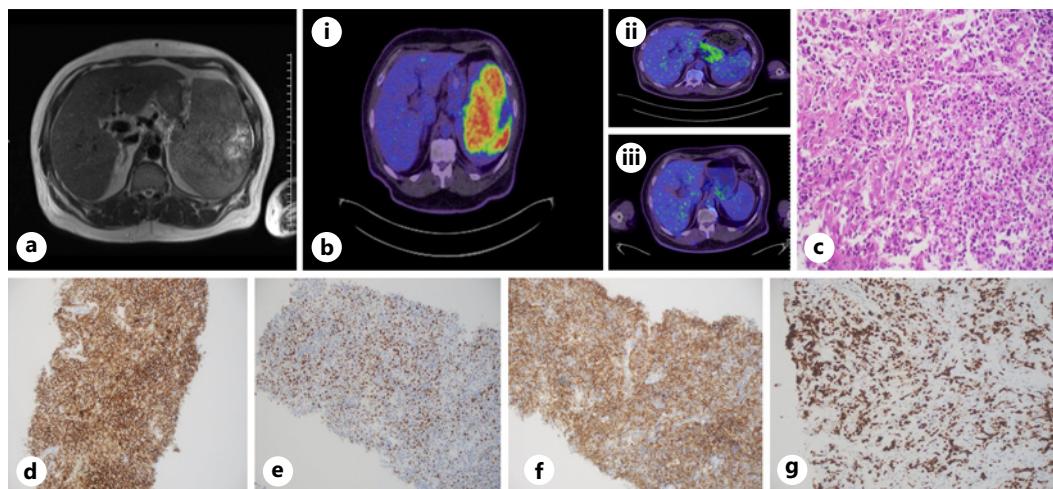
a Initial MRI of the abdomen. b-i Whole-body FDG PET CT. b-ii Interim NM whole-body PET CT. b-iii End of treatment, NM whole-body FDG PET CT. c Hypercellular lymphoid tissue (large lymphocytes and centroblasts). d Abnormal B lymphocytes showed strong positivity with CD20 at 20X power field. e Positive BCL6 at 20X power field. f Positive CD10 at 20X power field. g A Ki-67 index: 60%.
